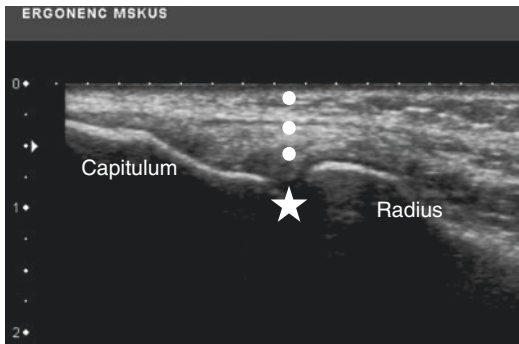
Long-axis sonogram of the radiocapitellar joint (*). Out-of-plane walk-down approach. White circle needle tip
